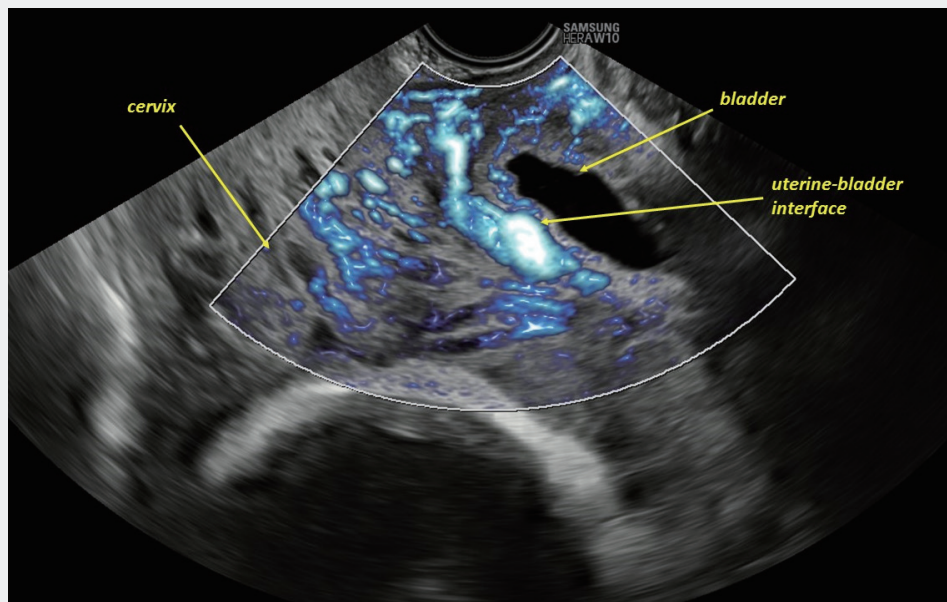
Transvaginal ultrasound image from a 34-week, para 3 woman referred due to suspected placenta accreta spectrum demonstrating the abnormal vascularization of the cervix and of the uterovesical interface with MV-Flow™ and LumiFlow™.
